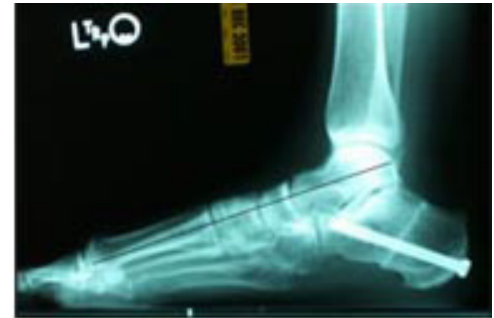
X-Rays After Reconstruction
